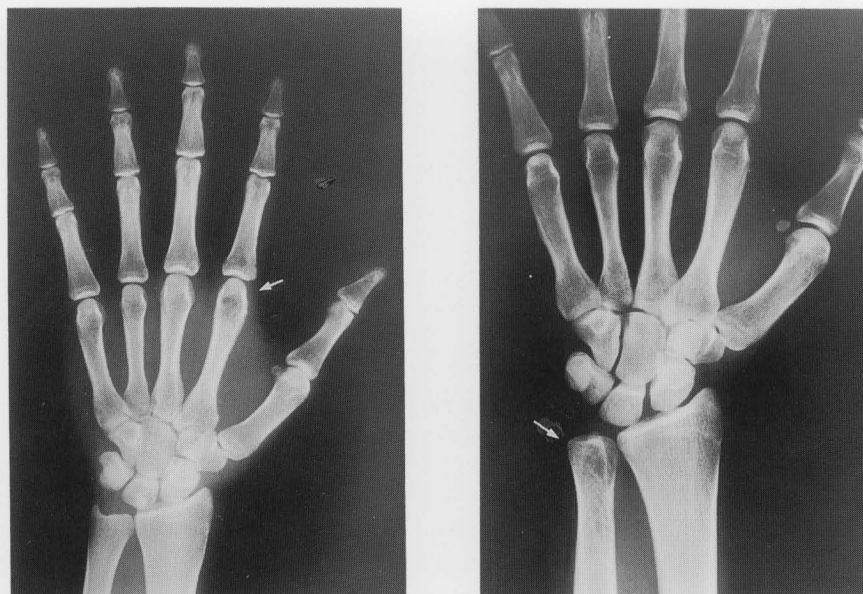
Plain roentgenograph showing osteolytic lesions within the left second metacarpus and right distal ulna.
